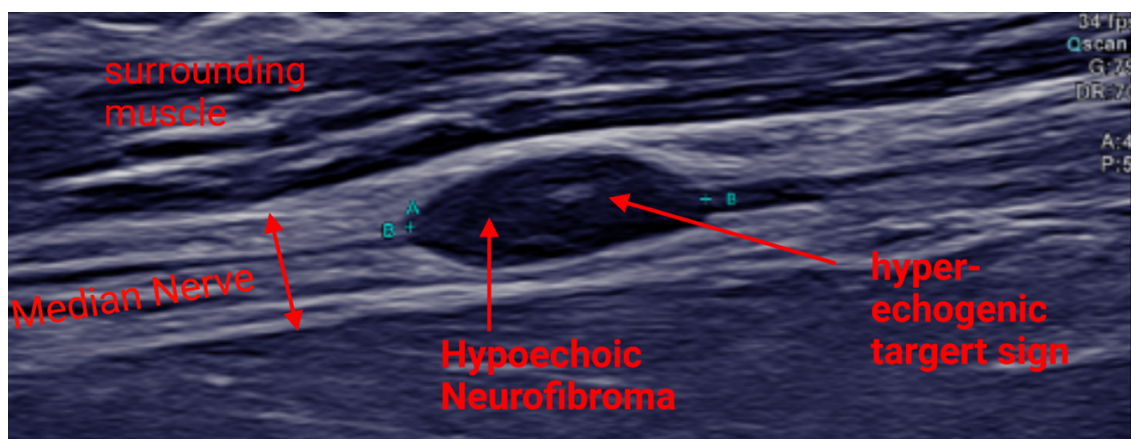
Neurofibroma in conventional B-mode-ultrasound (Own representation) Depicted is the median nerve with a hyperechoic neurofibroma which also shows a hyperechogenic target sign.
